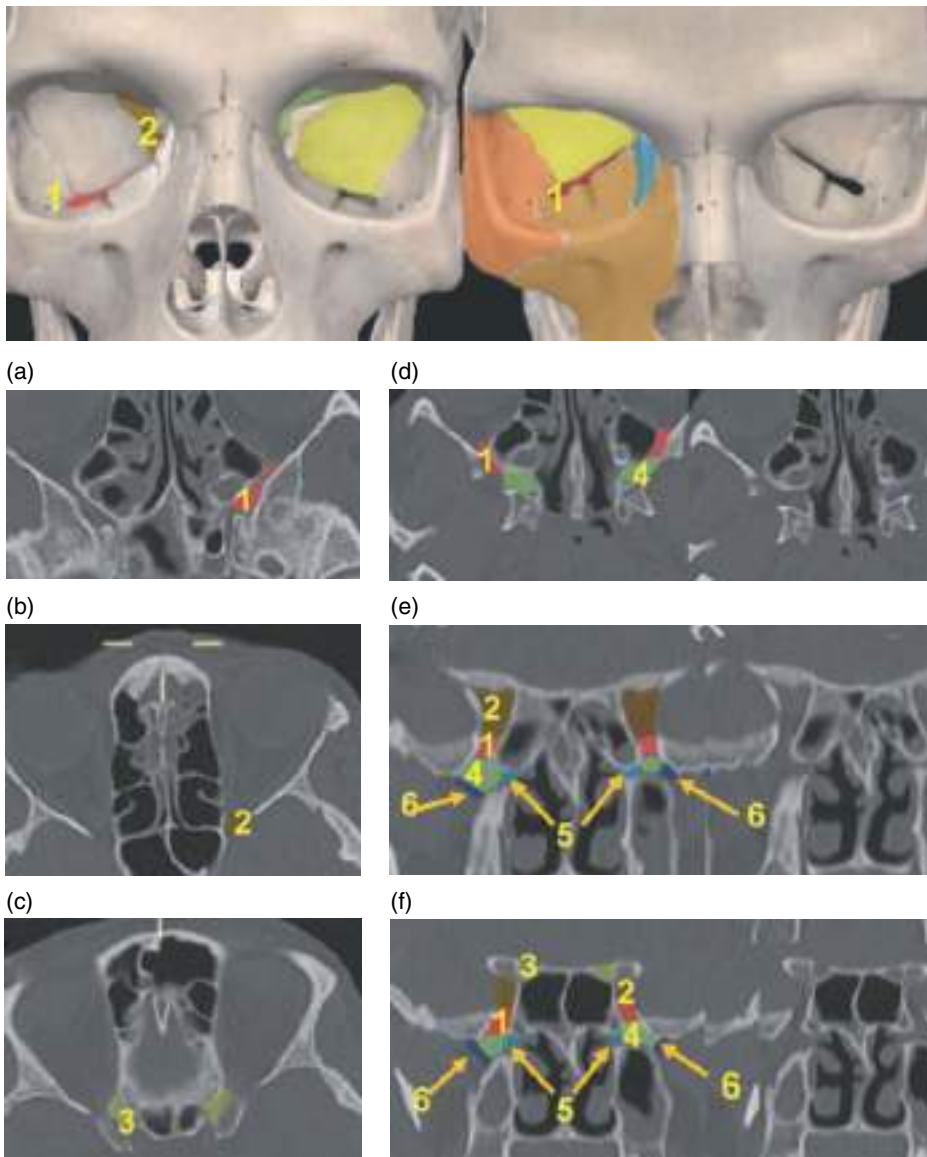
Orbital fissures. (l) Volume rendering of the orbits. (a–d) Axial noncontrast CT images of the orbit (bone window). (e, f) Coronal noncontrast MPR CT images (bone window). 1, inferior orbital fissure; 2, superior orbital fissure; 3, optic canal; 4, pterygopalatine fossa; 5, sphenopalatine foramen; 6, pterygomaxillary fissure. The inferior orbital fissure is in direct communication with the pterygopalatine fossa, located on the posterior part of the facial bones (between the posterior wall of the maxillary sinus and the pterygoid process). The pterygopalatine fossa (4) is an important pathway for the extension of lesions. It communicates with the infratemporal fossa of the masticator space laterally via the pterygomaxillary fissure (6), and with the nasal fossa medially via the sphenopalatine foramen (5). The superior orbital fissure communicates with the cavernous sinus.
